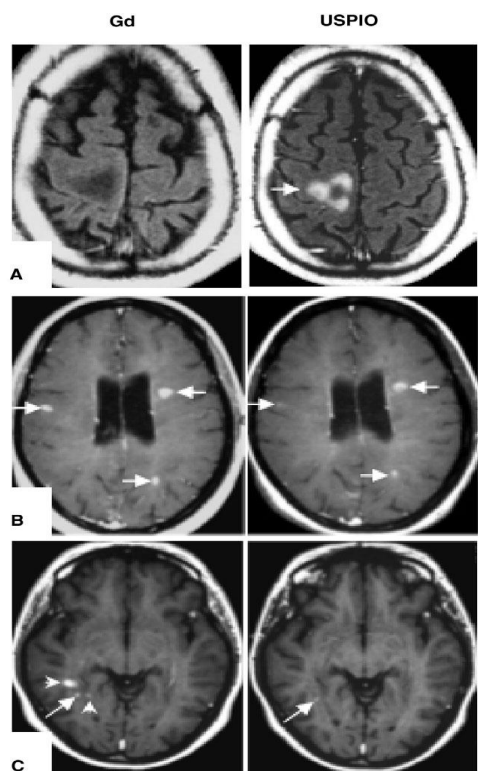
MRI patterns of macrophage brain infiltration with ultrasmall superparamagnetic iron oxide particles (USPIO) (left panels) and blood-brain barrier (BBB) leakage with gadolinium-chelate (Gd) (right panels) in acute multiple sclerosis [76].
